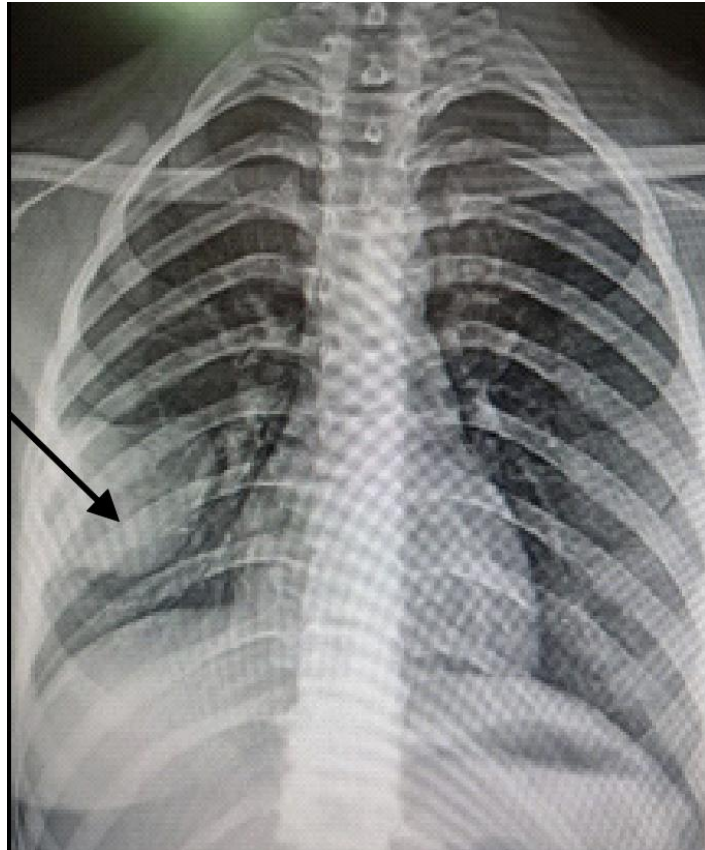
Chest Radiograph Showing A Right-Sided Basal Pleural Opacity Black Arrow
